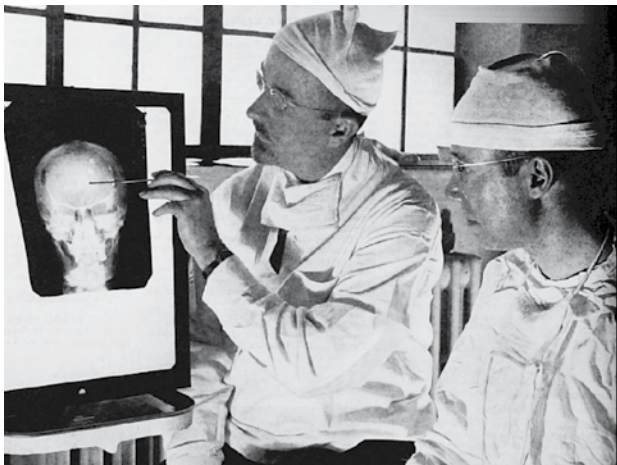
Dr Walter Freeman (1895–1972), left, examining an X-ray before psychosurgery—the cutting of the brain in an attempt to remove ‘undesirable aggressive behaviours’.
